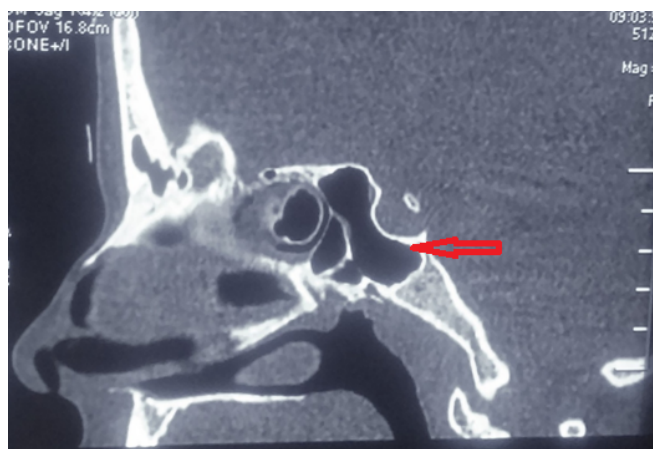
CT scan of PNS - Sagittal section showing Sellar type of Sphenoid sinus pneumatization.
